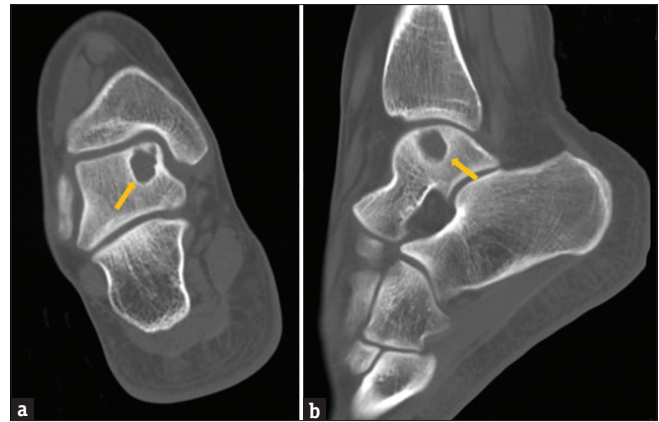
CT examination revealed a large cyst lesion over medial talar dome (arrow). (a) AP view and (b) lateral view depicted a Raikin zone 4 lesion
